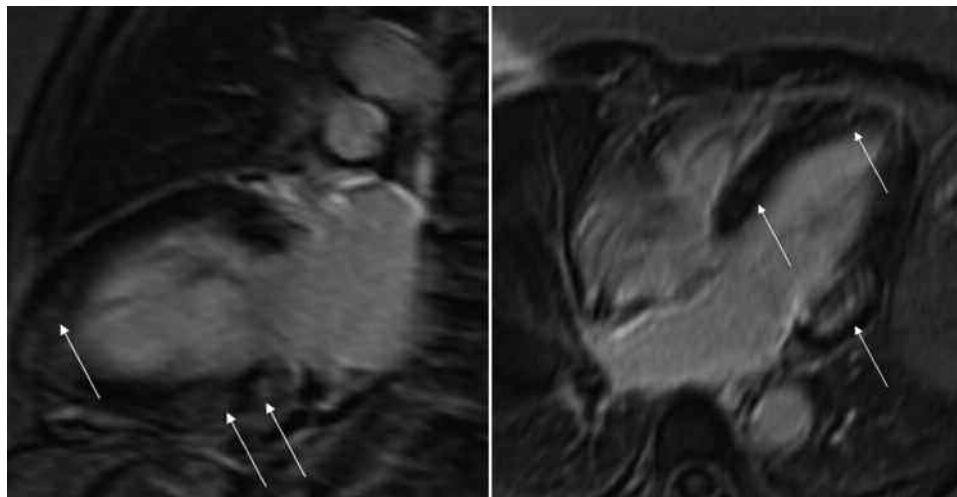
Magnetic resonance imaging shows decreased viability of the left ventricle in a nonvascular pattern (arrows indicate delayed gadolinium enhancement). Left panel: modified 2-chamber view; right panel: 4-chamber view.
